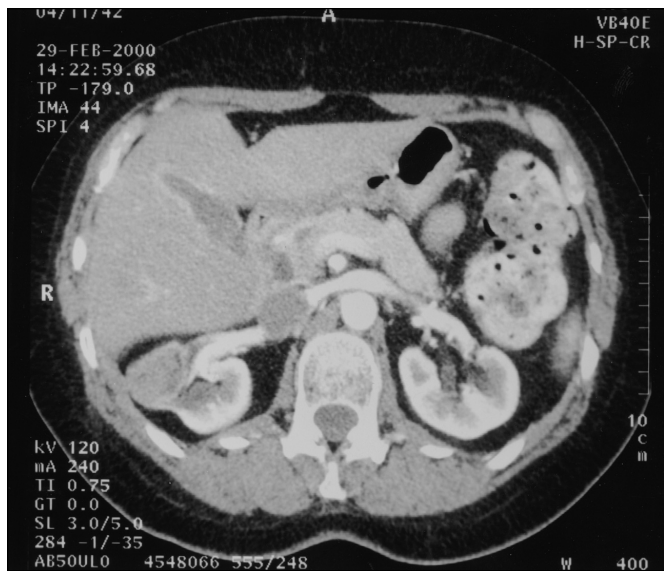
CT scan showing the tumor involving the diaphragm.
